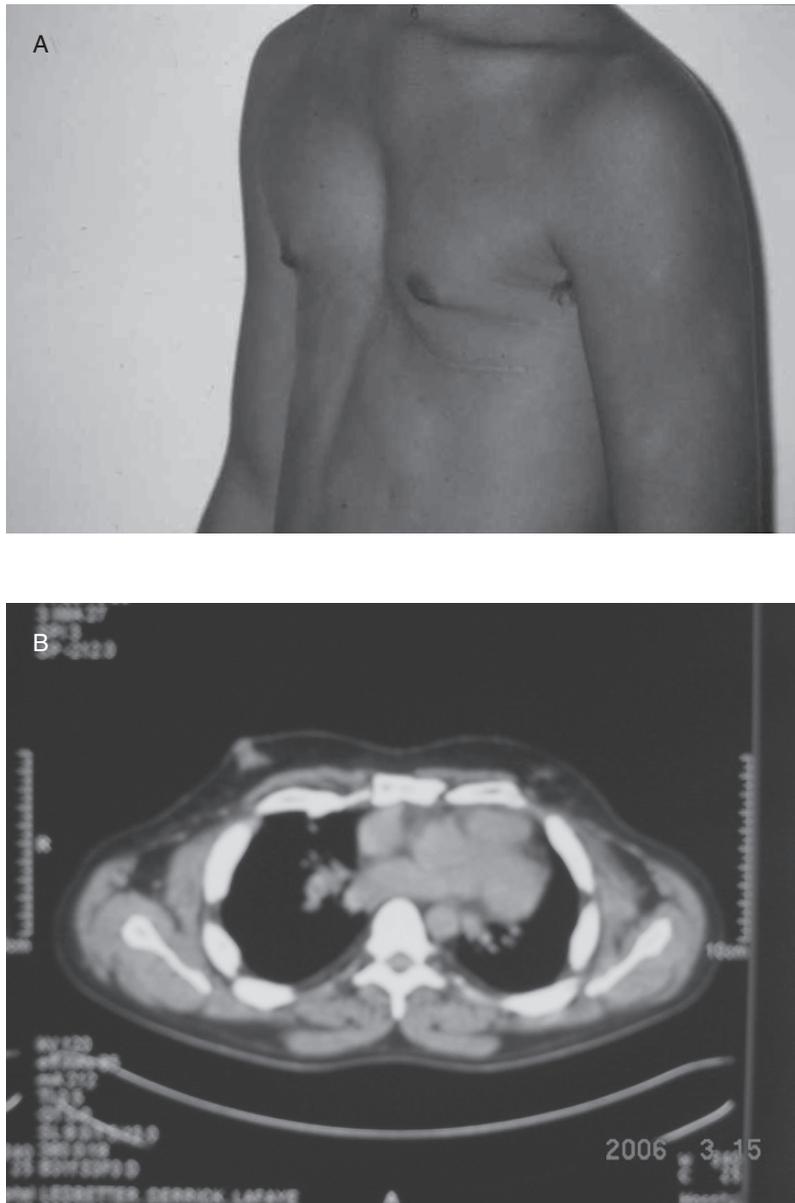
Clinical photograph and CT scan of patient with recurrent pectus excavatum 17 years after repair, showing ossification of the costal cartilages and a narrow upper chest cavity.
